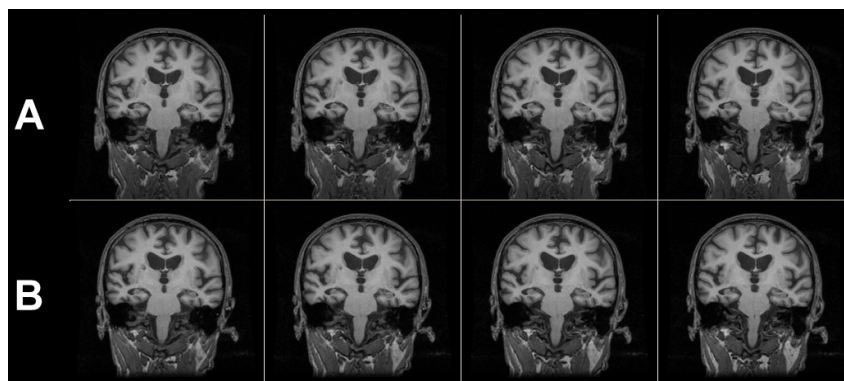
MRI – MRI registration result (two examinations of the same patient).
